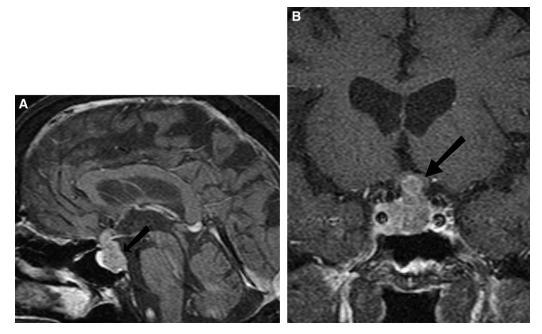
(A) Sagittal reconstruction of post-contrast T1-weighted magnetic resonance image (MRI) of the brain, showing a large, enhancing mass within the pituitary fossa (black arrow) in this patient with a history of renal cell carcinoma 5 years earlier. The finding is consistent with hypervascular metastasis. (B) Coronal reconstruction, postcontrast, T1-weighted MRI of the same patient, demonstrating enhancing pituitary mass (black arrow), consistent with renal cell carcinoma recurrence.
